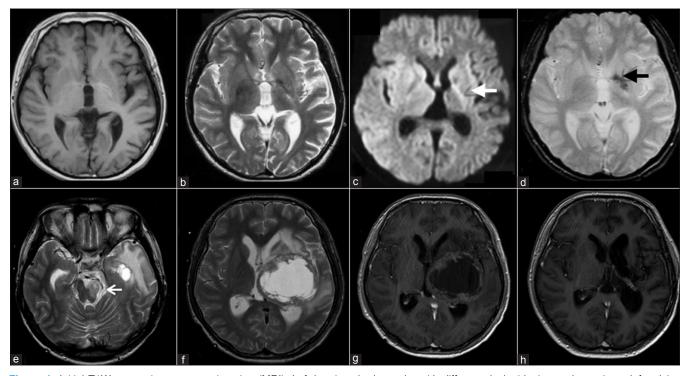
Initial T1W magnetic resonance imaging (MRI): Left hemicerebral atrophy with diffuse sulcal widening and prominent left sylvian fissure without ventricular enlargement (a); T2W: Subtle hyperintense signal changes at the left globus pallidus and posterior limb of the internal capsule (b); DWI: Restricted diffusion of the same areas (white arrow, c) and GRE: Hypointense signals ("blooming") (black arrow, d); 2 years later: Large left basal ganglia cystic lesion (T2W with left cerebral peduncle atrophy, white thin arrow (e); T2W (f); contrast T1W (g); 6-month post-treatment contrast T1W MRI showed no recurrent tumor (h)
